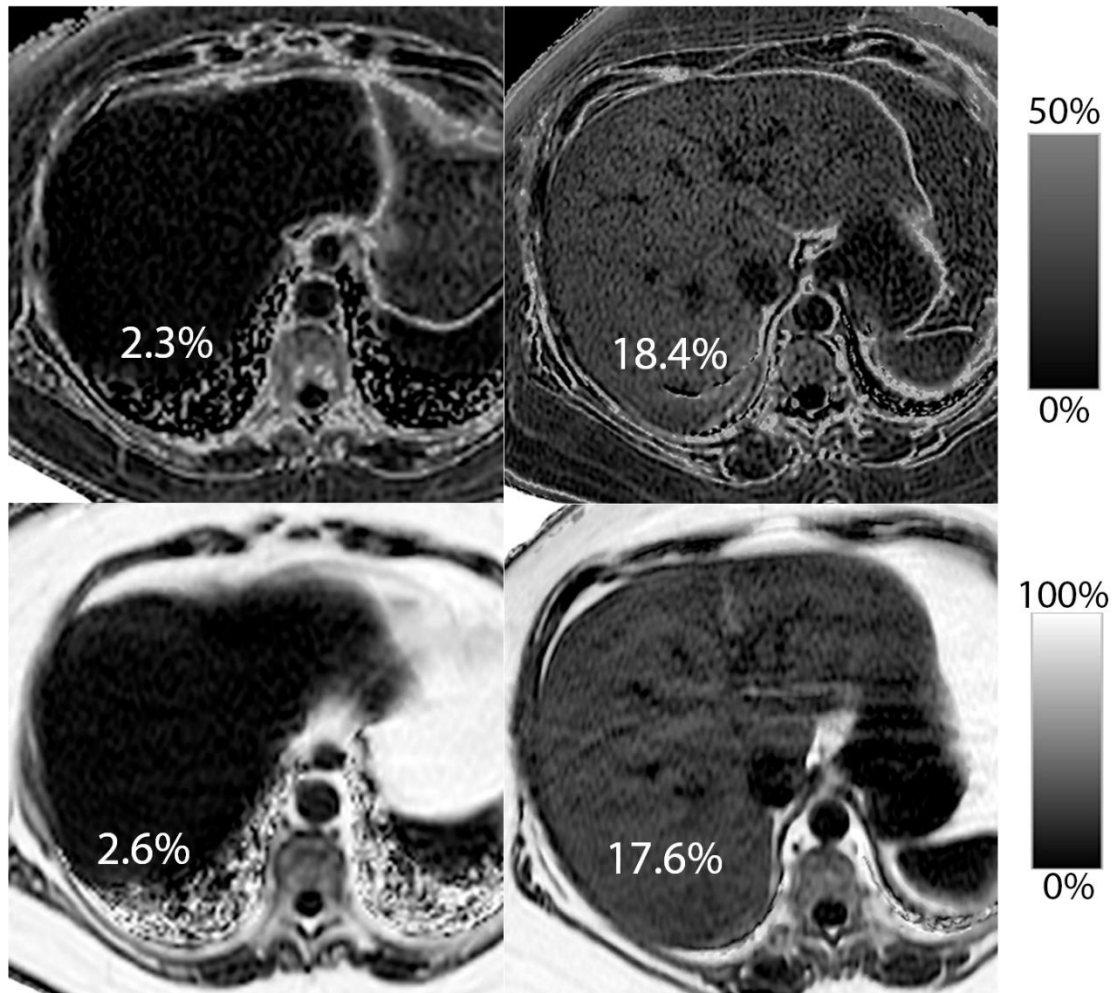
Magnetic resonance imaging (MRI) proton density fat fraction (PDFF) maps generated by magnitude-based magnetic resonance imaging (MRI-M, top row) and complex-based magnetic resonance imaging (MRI-C, bottom row) for subjects without (left column: 55-year old woman, body mass index 33.2 kg/m^2) versus with (right column: 58-year old woman, body mass index 44.7 kg/m^2) hepatic steatosis. Notice that MRI-M estimates PDFF from 0-50% whereas MRI-C estimates PDFF from 0 to 100%, as reflected in the scale bars. As a result, adipose tissue appears dark on MRI-M maps but bright on MRI-C maps. Despite these differences, close PDFF agreement is observed in the liver.
